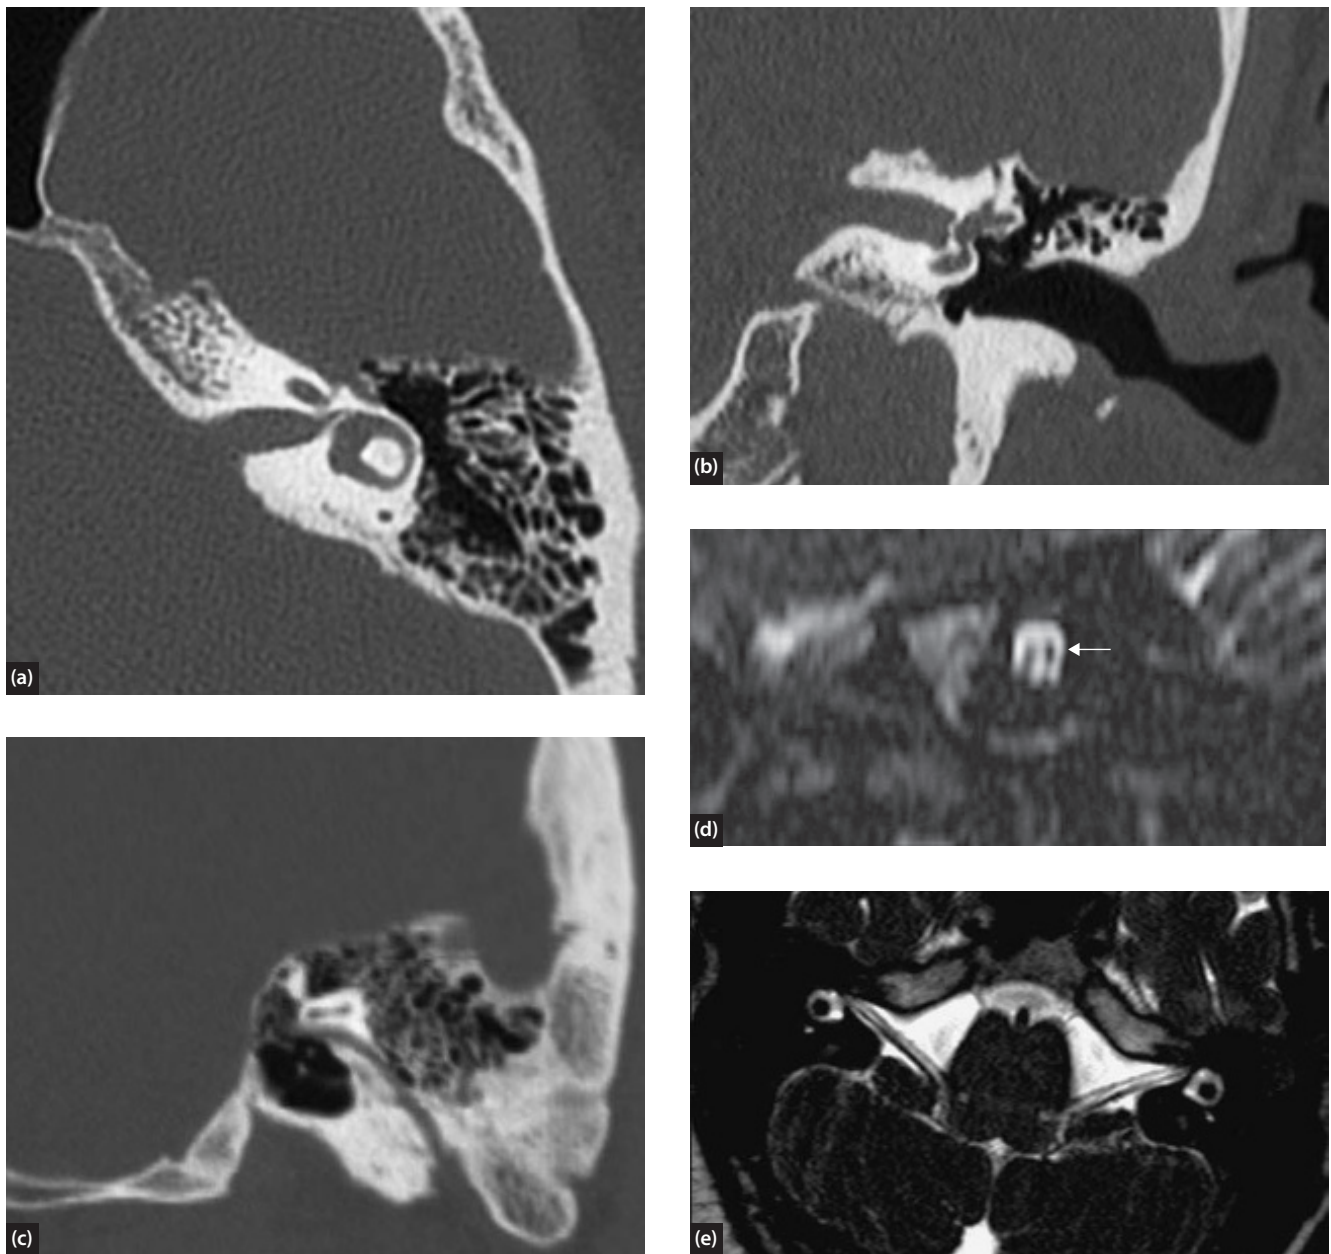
(a) Axial CT scan of the labyrinthine segment of the facial nerve and first genu; (b) coronal CT of tympanic segment of facial nerve which lies just inferior to the lateral semicircular canal; (c) oblique sagittal CT view of the mastoid segment of the facial nerve and second genu; (d) T2 DRIVE oblique sagittal MRI of facial nerve in the IAM (arrowed); (e) T2 DRIVE axial MRI of facial nerve in the IAM running alongside the superior vestibular nerve.
